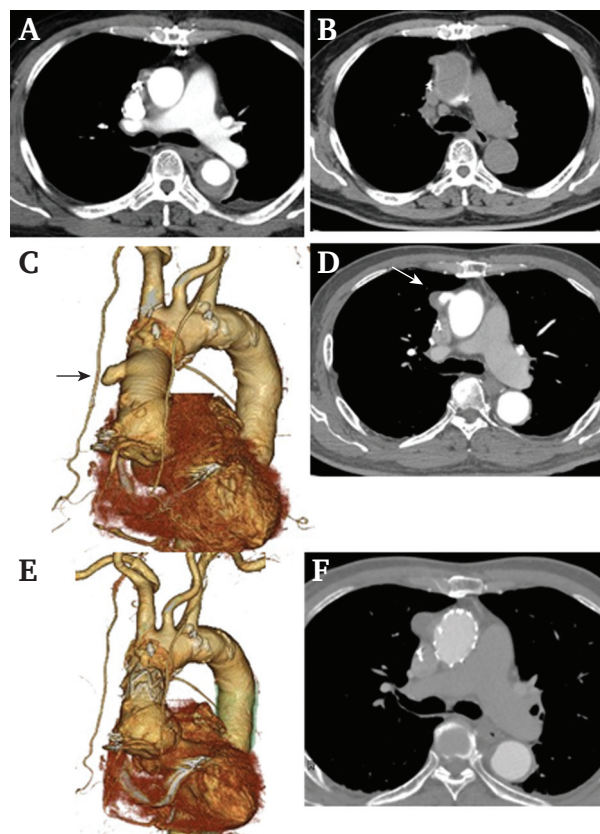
(A) Computed tomography after initial ascending aortic replacement and omentopexy. No contrast enhancement in the side branch. (B) There was no pseudoaneurysm formation in the side branch one year previously. (C) Pre-operative three dimensional computed tomography image showing the pseudoaneurysm arising from the side branch (black arrow). (D) Axial image of the pseudoaneurysm (white arrow). (E) Post-operative computed tomography image. (F) There was no endoleak on axial imaging.
